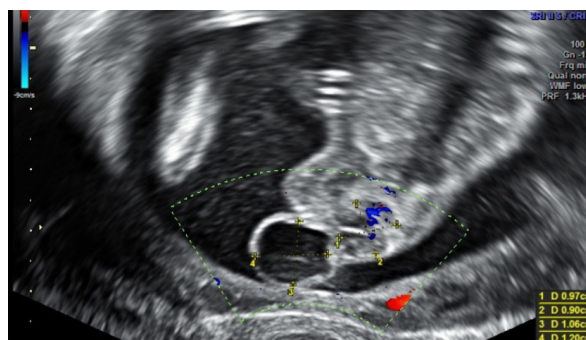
Vascularisation of SCT at 17 weeks' (ultrasound TV head imaging)
